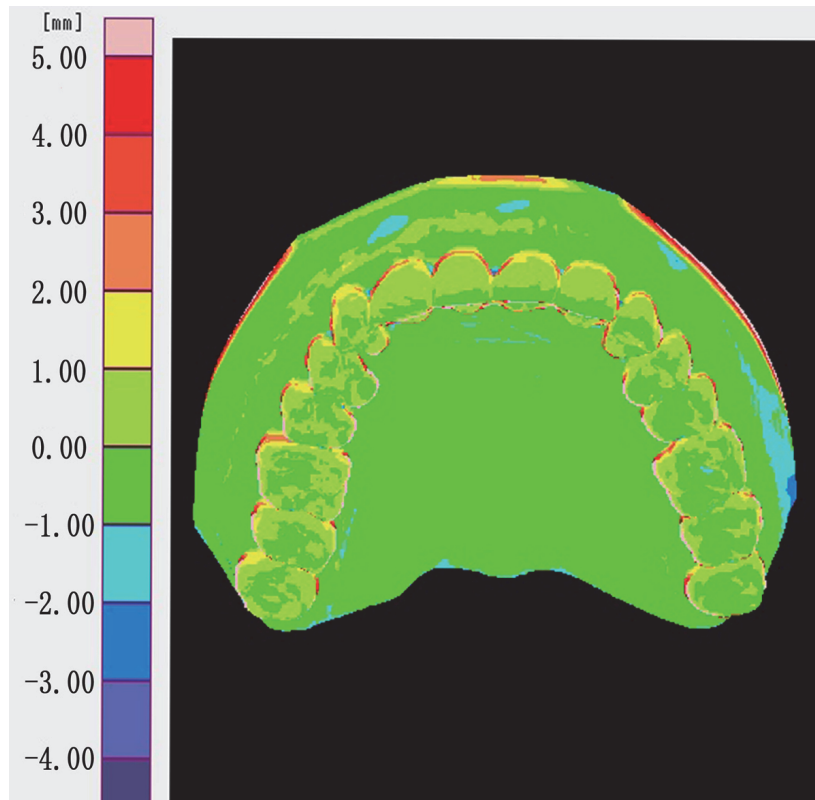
The distance between the dental model and CT images after integration. Warm colors (yellow, orange, and red) indicate positive change, and cold colors (blue and purple) indicate negative changes. Green indicates no change. (Positive change means the dental model image is located in front of the CT image and negative change means the dental model image is located behind the CT image.)
